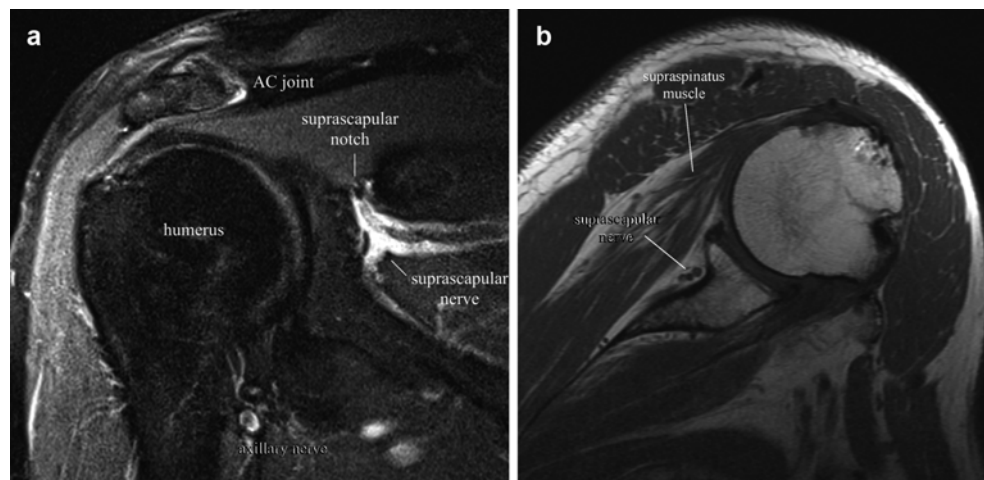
MRI anatomy of the suprascapular notch: (a) T2-weighted coronal view; (b) T1-weighted axial view (Image courtesy of Andrea Trescot, MD)
